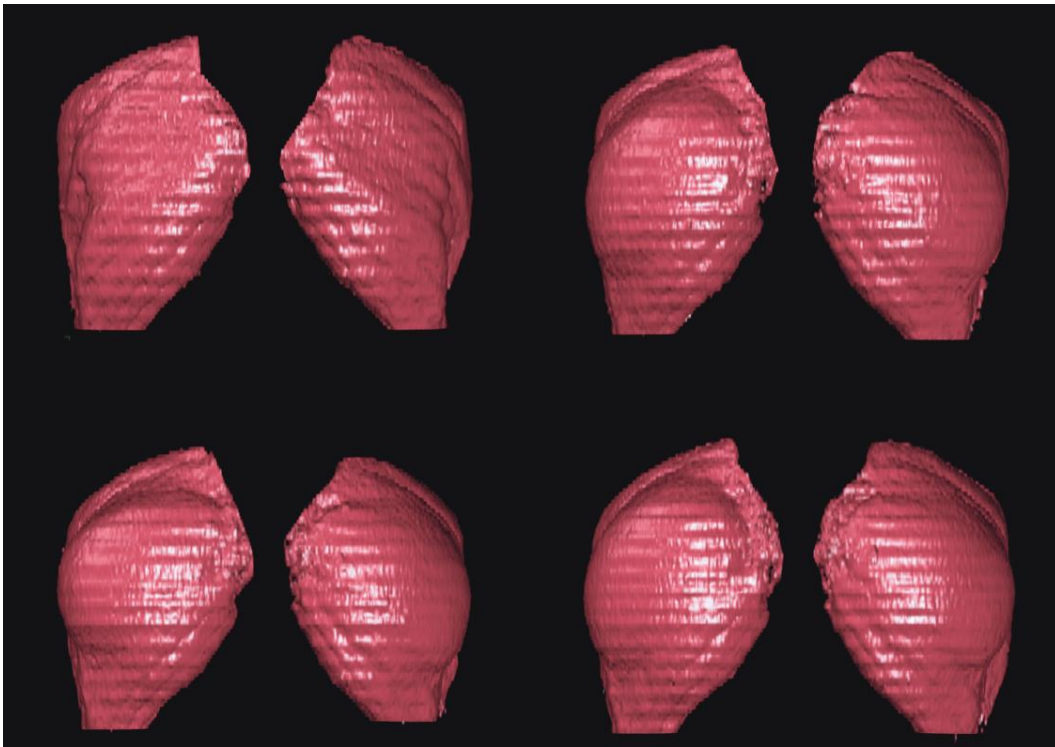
CT scan and 3D gluteal reconstruction (Clockwise direction): pre- operative; after 3, 6, and 12 months of the surgical procedure.
